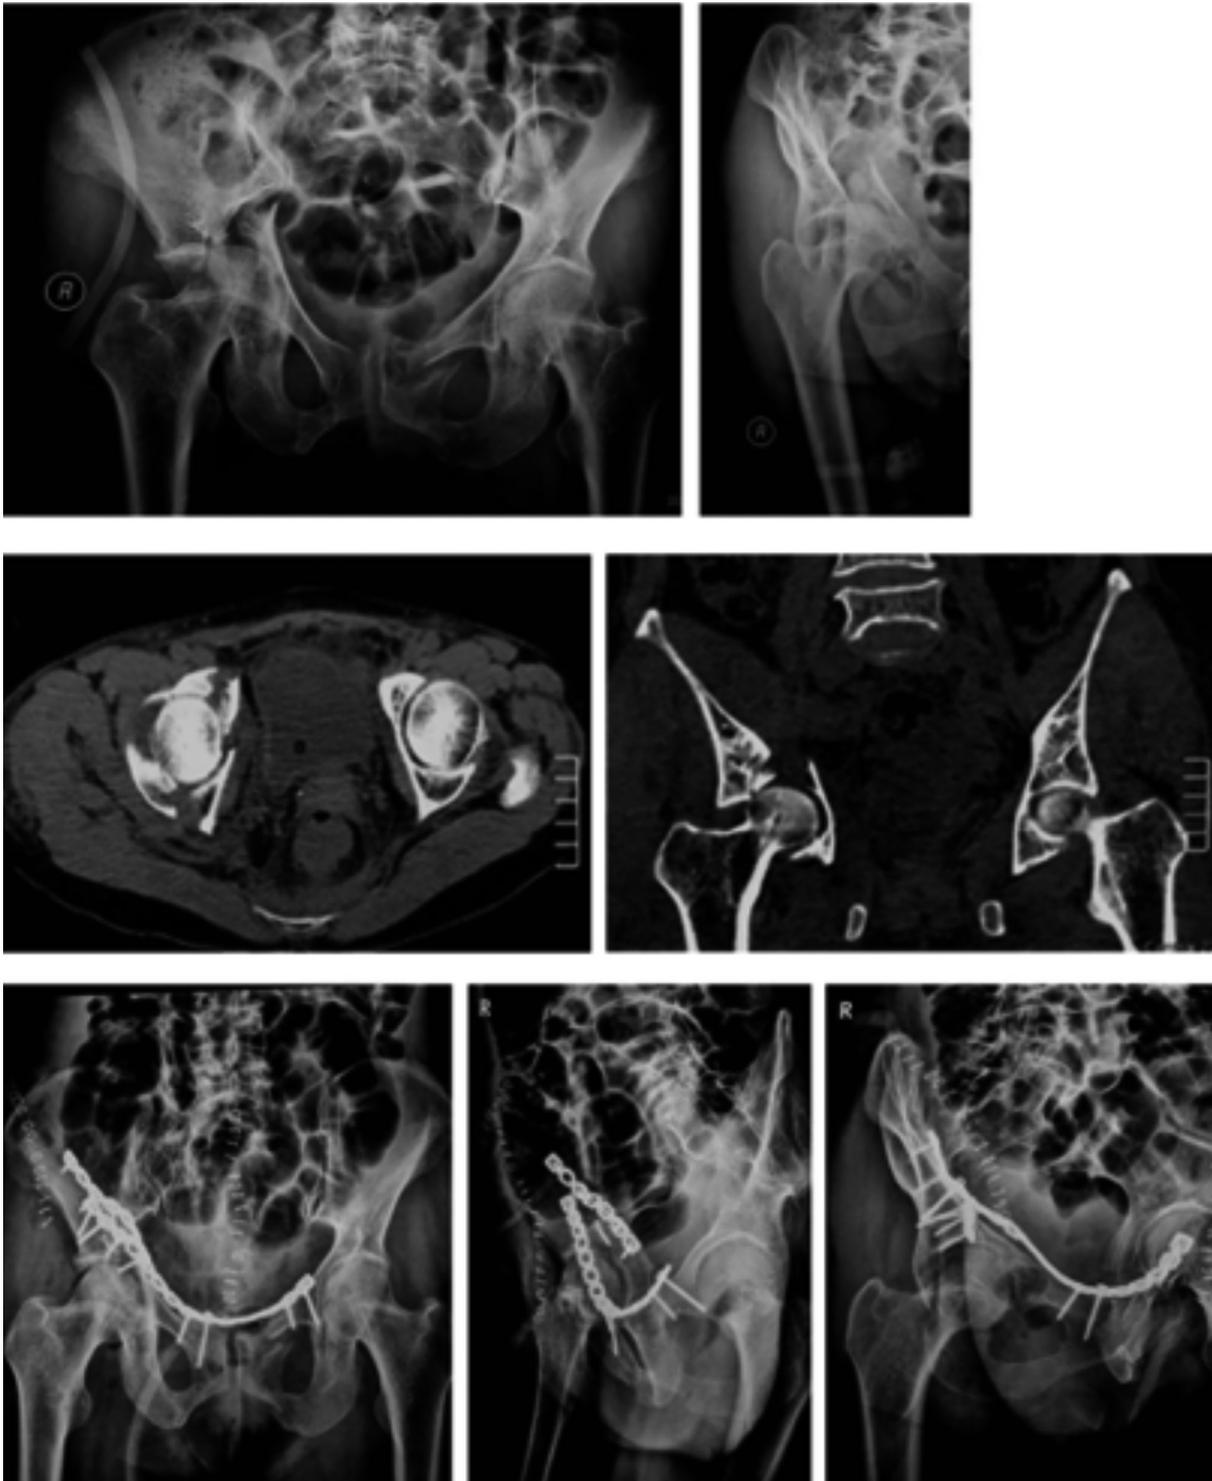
A 63-year-old female had a T-shaped right acetabular fracture caused by a fall-related injury and underwent open reduction and internal fixation. The posterior column was fixed with a plate extending from the medial side of the ilium to the ischial tuberosity. Postoperative X-ray shows anatomical reduction of the acetabulum
